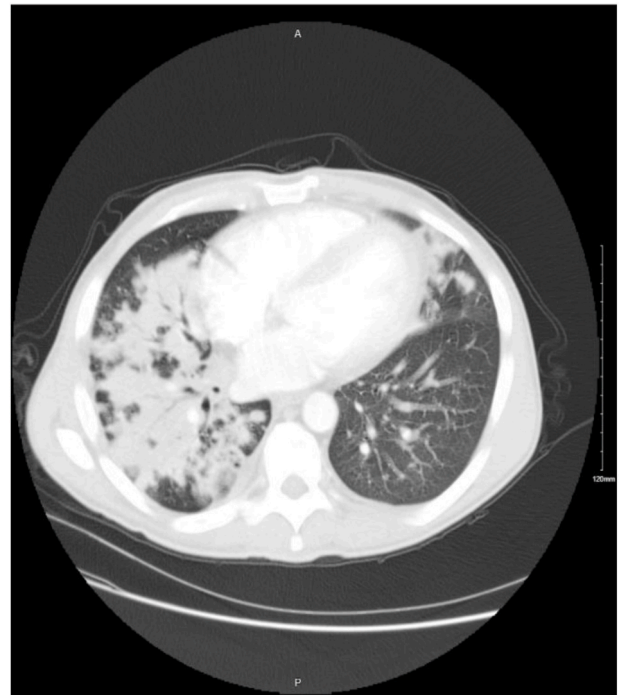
CT chest (day 12) showing stable infiltrates.
